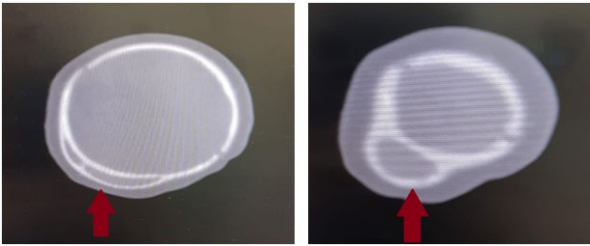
CT brain images of the patient
